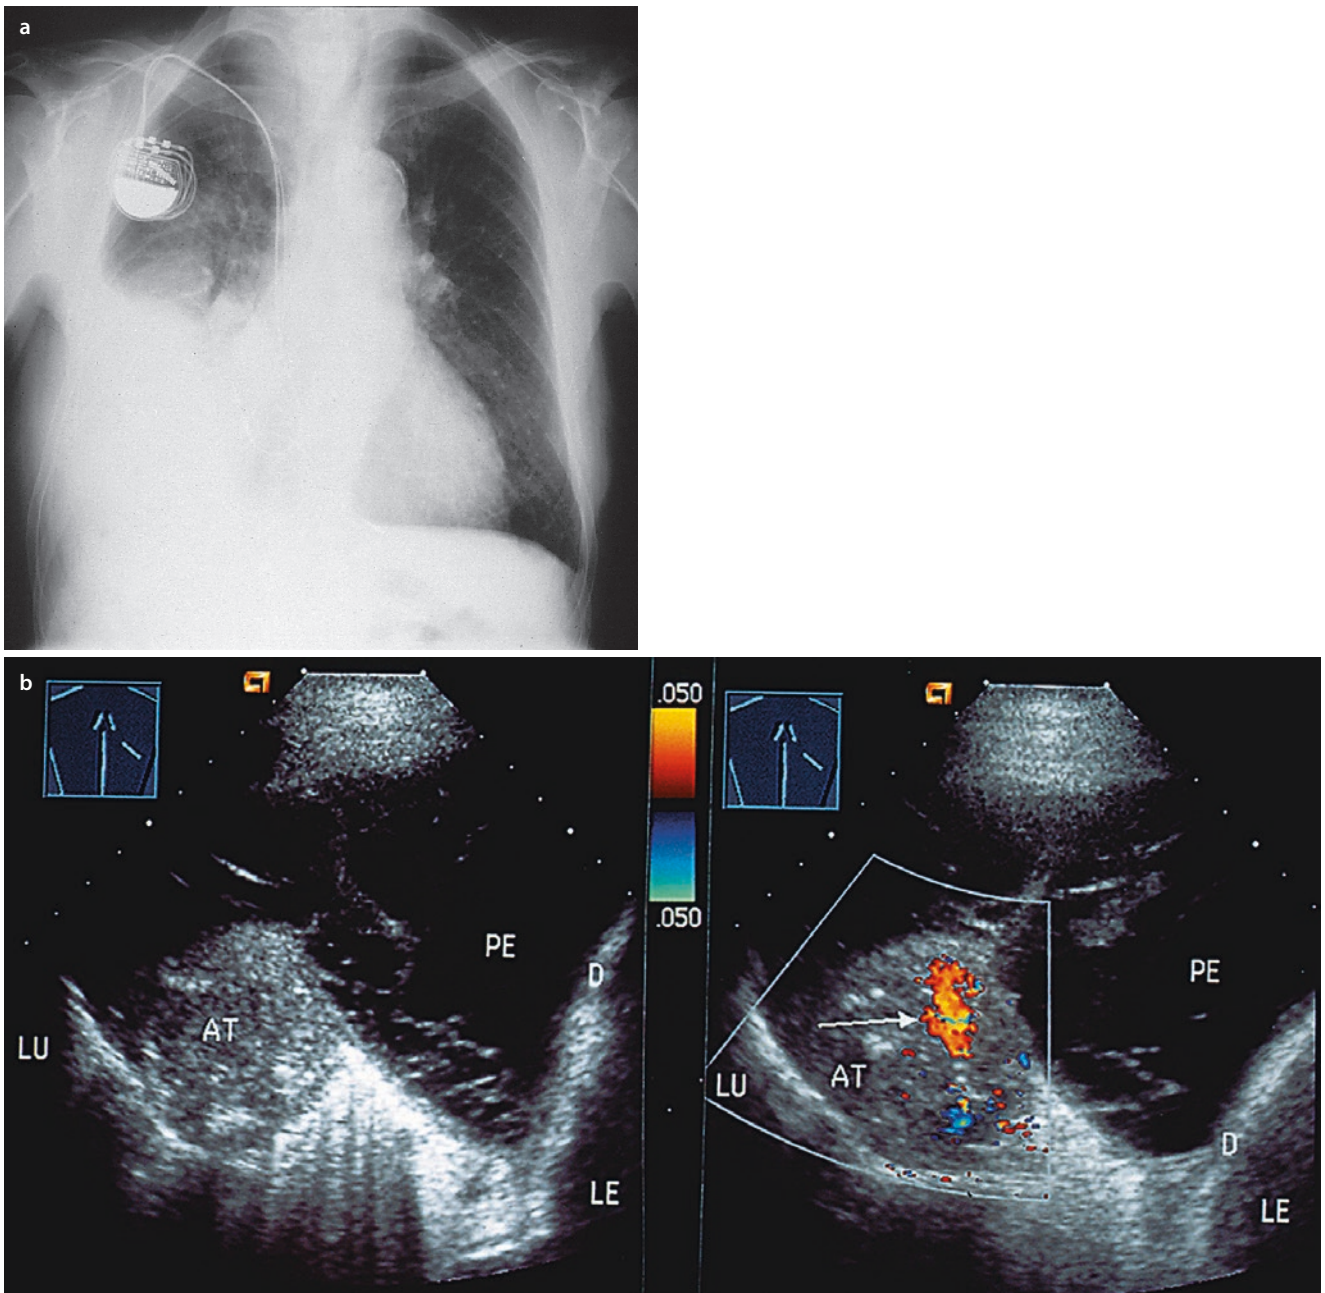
A 75-year-old man with heart failure. a Chest X-ray: shadow in the region of the right caudal lung. b Sonography: right dorsal echo transmission shows a marked and partly septated pleural effusion (PE), and a circular hypoechoic consolidation of parts of the lung (AT). On color-Doppler sonography one finds pronounced flow
